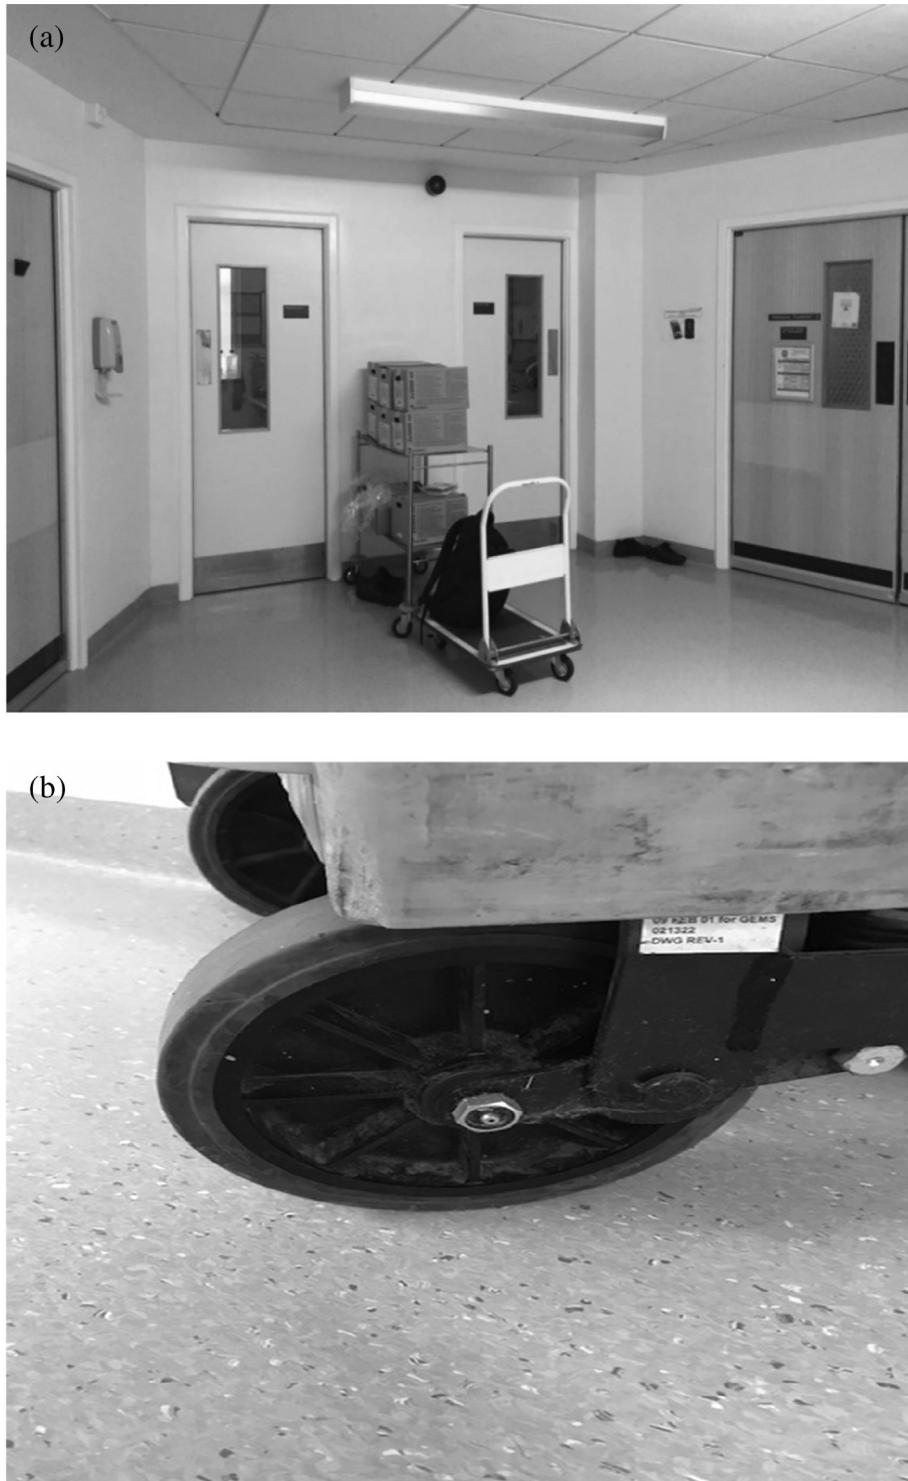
Positive environmental samples Round 1. (a) A settle plate placed on a trolley between Burn Intensive Care Unit Rooms 1 and 2. (b) A swab from the right rear wheel of a trolley housing the portable x-ray machine which was stored in the communal corridor outside the operating theatre.
